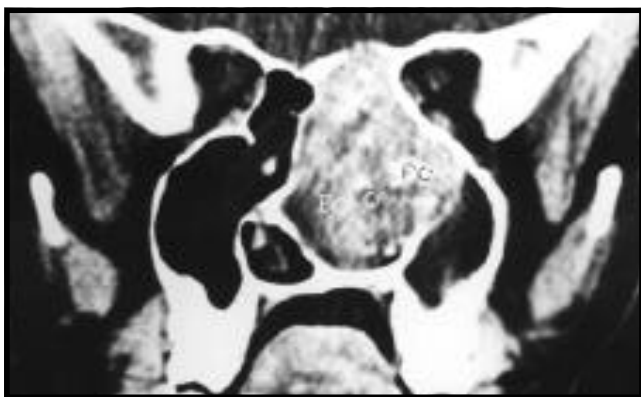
An axial CT scan showing soft tissue mass in the left maxillary, ethmoidal and sphenoidal sinuses with marked typical calcifications in the sinuses; marked A, B, and C.
